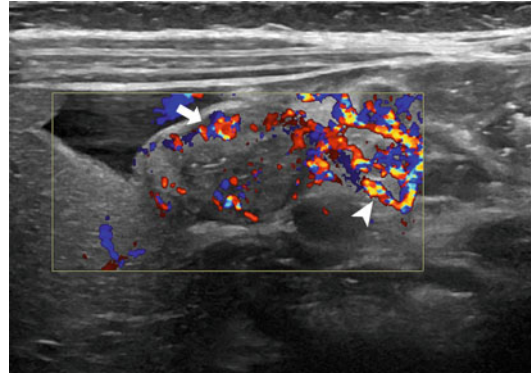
Color Doppler exam in newborn, with early state of NEC, shows the thickened and hypervascular wall bowel (*arrow*); note the hypervascularization of the mesenteric perivisceral tissues (*arrowhead*)
